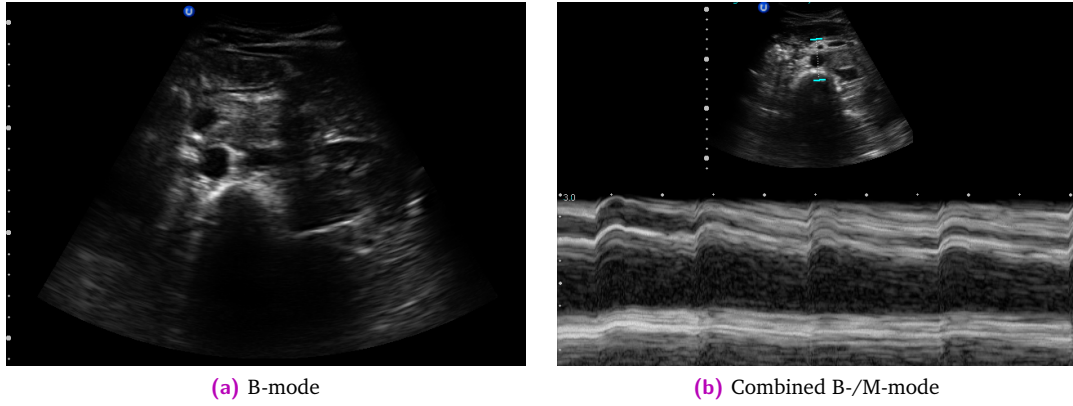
Exemplary brightness images of a healthy human abdomen (female, 28), acquired with a curvilinear probe and clearly visualizing the aorta. While B-mode frames assemble numerous scanlines in 2D, thus generating a spatial view, M-mode presents parts of a single scanline as selected by the sonographer (*blue bars*) over time and thus facilitates a temporal view.
